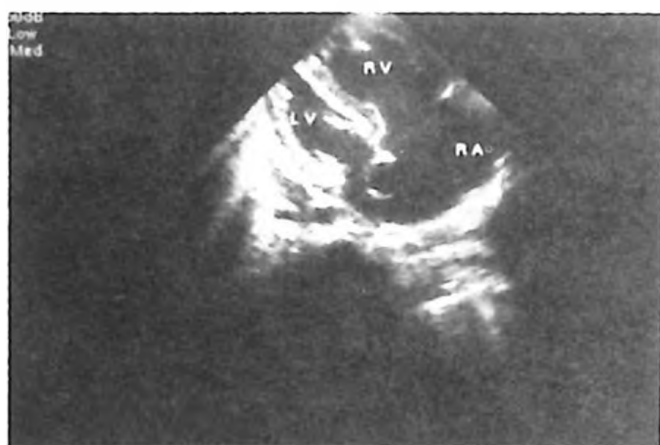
Case 1. Two-dimensional echocardiogram in apical four-chamber view. Atrial septal aneurysm protruding into left atrium is noted.
